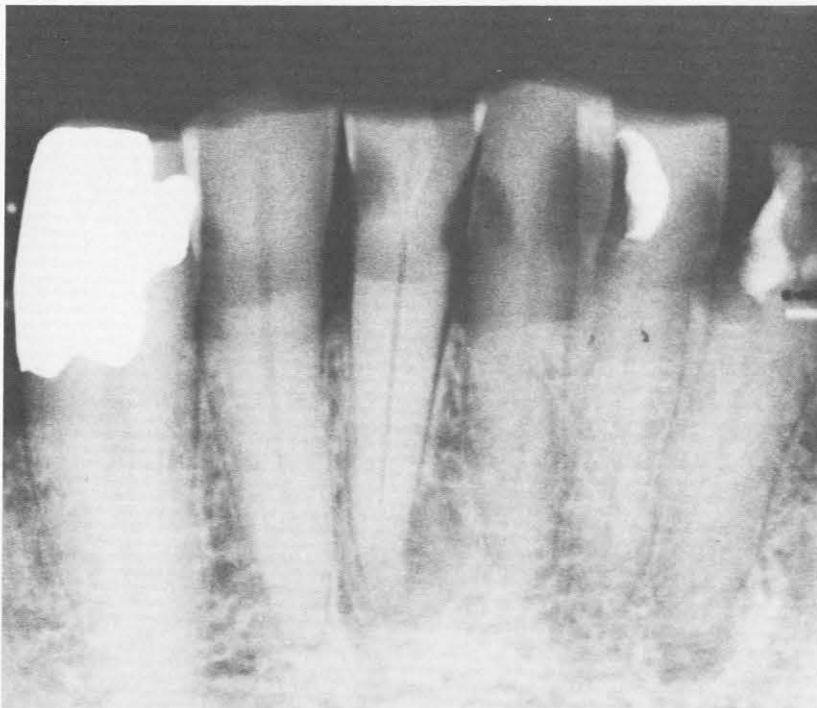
Periapical lesions, teeth 22 and 25, beginning x-ray
